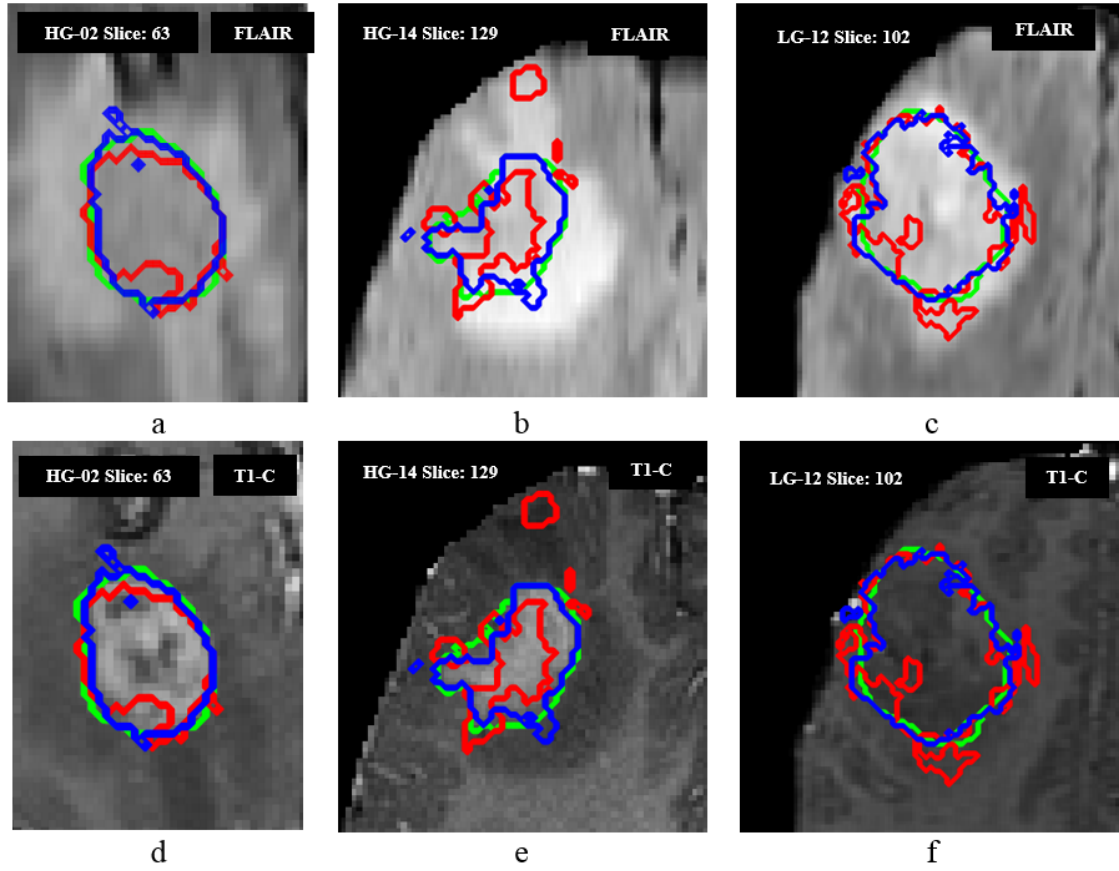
Comparison between single modality and multimodal segmentation of core. a-c) FLAIR, d-f) T1-C.
